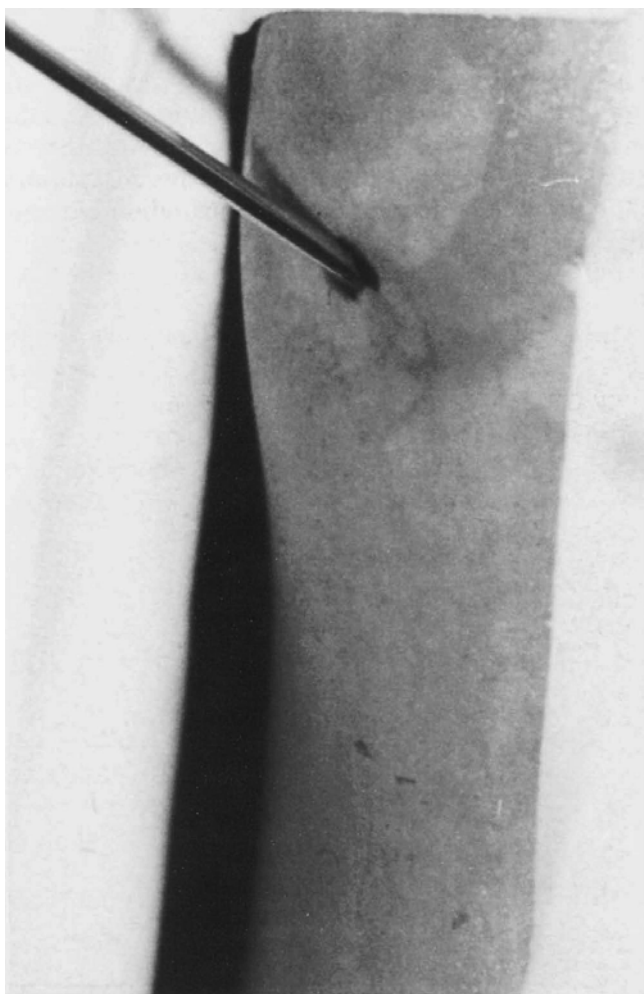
Targeted Jamshidi needle biopsy under radiographic control
